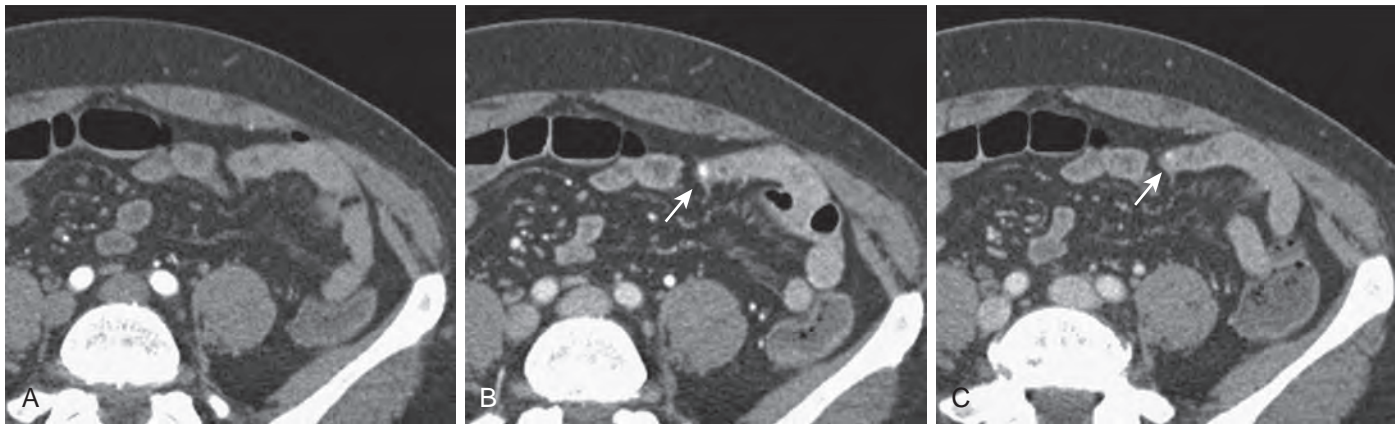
Angioectasia. A 65-year-old woman with multiple episodes of melena. Arterial (A), enteric (B), and delayed (C) phase axial images from a multiphase CTE study demonstrate a focal, less than 5 mm nodular area of enhancement in the distal jejunum (arrows), undetectable on the arterial phase and brightest on the enteric phase. Angioectasia was subsequently ablated during balloon-assisted endoscopy. (From Huprich J, Barlow J, Hansel S, et al: Multiphase CT enterography of small bowel vascular lesions. *AJR* 201:65–72, 2013.)
